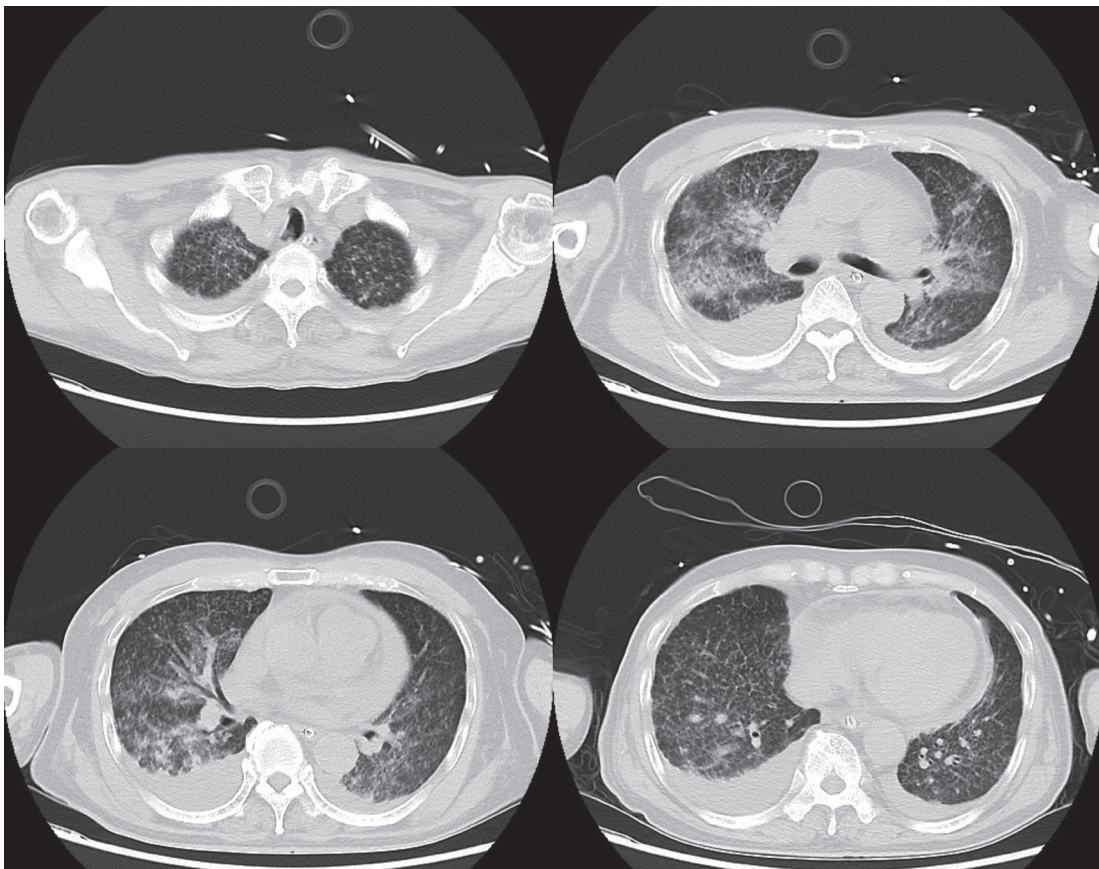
Chest computed tomography.
